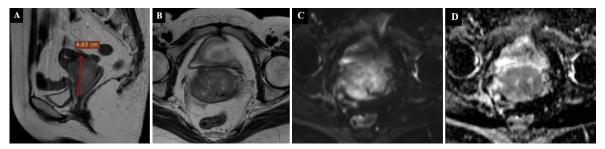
Pelvic MRI Examination of Case 2
